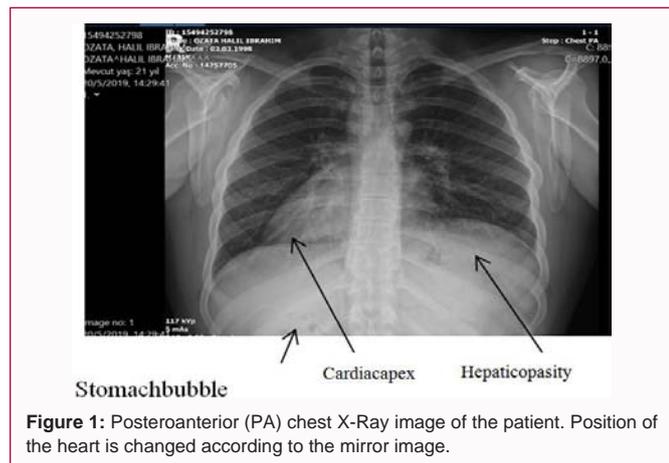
Posteroanterior (PA) chest X-Ray image of the patient. Position of the heart is changed according to the mirror image.
